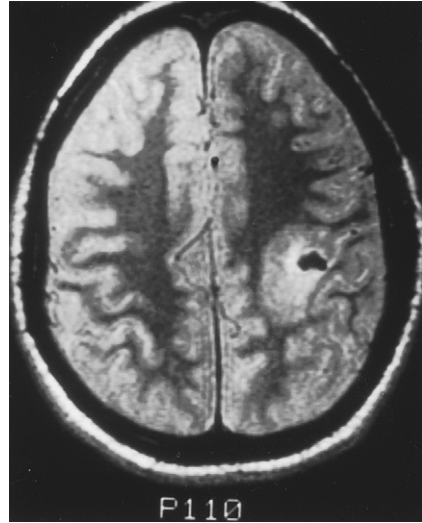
Small acute hematoma in the left parietal subcortical white matter caused by aspergillus infection. The markedly decreased signal on this T2-weighted image is secondary to deoxyhemoglobin, which is difficult to differentiate from hemosiderin without a T1-weighted image. The vasogenic edema is a clue to the acute nature of the lesion.
